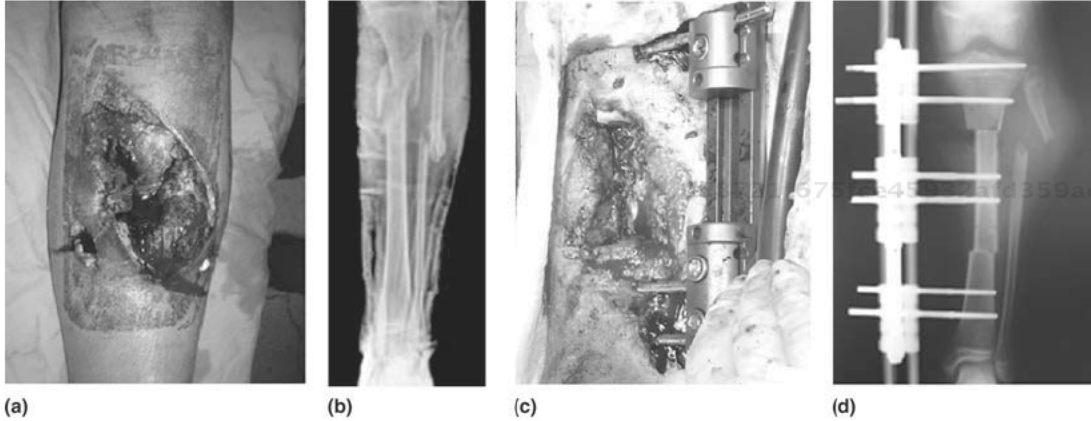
Fractures and surgical treatment. (a) Photograph of injury. (b) X-ray of the fracture. (c) Square osteotomy in the defect area and subperiosteal distal corticotomy in order to carry out the bone elongation. (d) Acute shortening of the limb due to a square osteotomy in the defect area. (e) Soft tissues handling and primary closure. (f) Through (i) Sequence showing elongation of bone by 12 cm (0.25 mm every 6 hours) and healing of the soft tissue. (j) Soft tissue cicatrization and restored tibia length. (k) and (l) Treatment evolution at 24 weeks after withdrawal of the external fixation device. The patient reported no pain and exhibited complete mobility. Courtesy of Victor Manuel Peña-Martínez, M.D.
